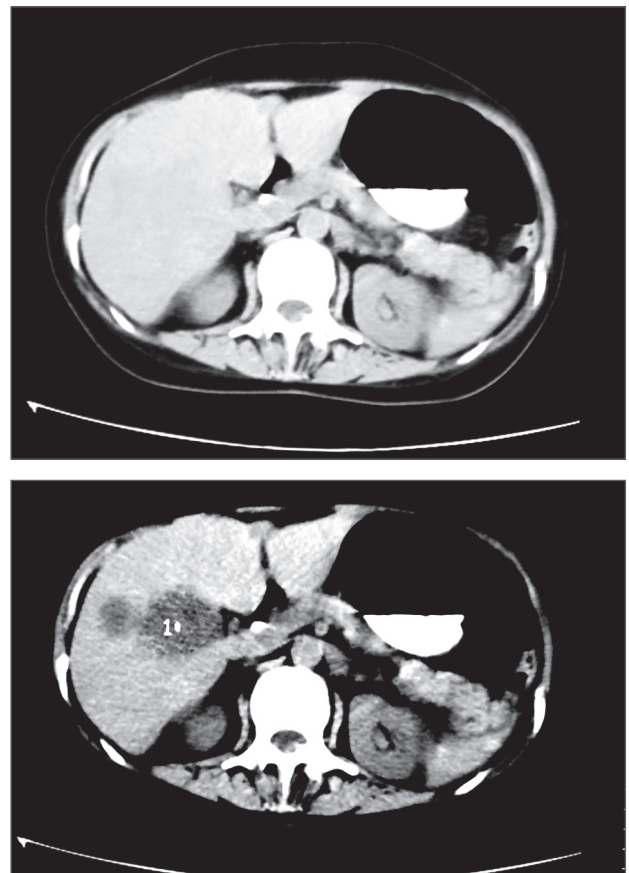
Case #2: CT scans reveal the development of massive hepatic metastatic lesions, 20 days after the first administration of trabectedin.
